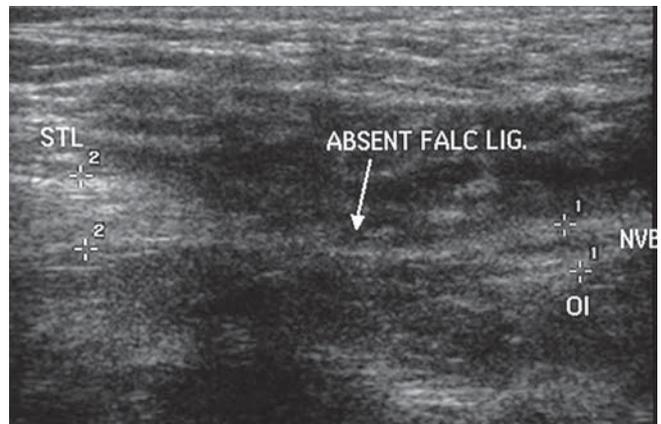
Transverse ultrasound scan showing absent falciform ligament.
